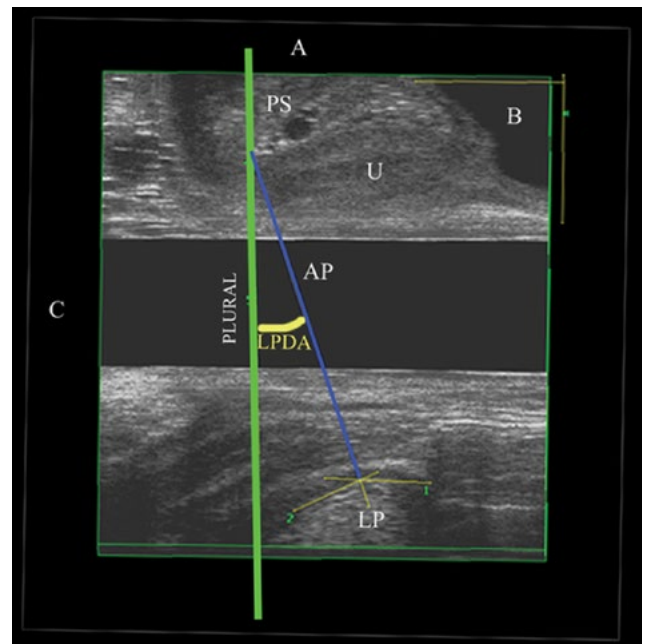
Levator plate descent angle (LPDA) in mid-sagittal view by transvaginal 360° ultrasound. Abbreviations: A, anterior; B, bladder; C, caudad; LP, levator plate; LPDA, levator plate descent angle; PLURAL, pubic levator ultrasound reference assessment line (green line); PS, pubic symphysis; U, urethra (1).
